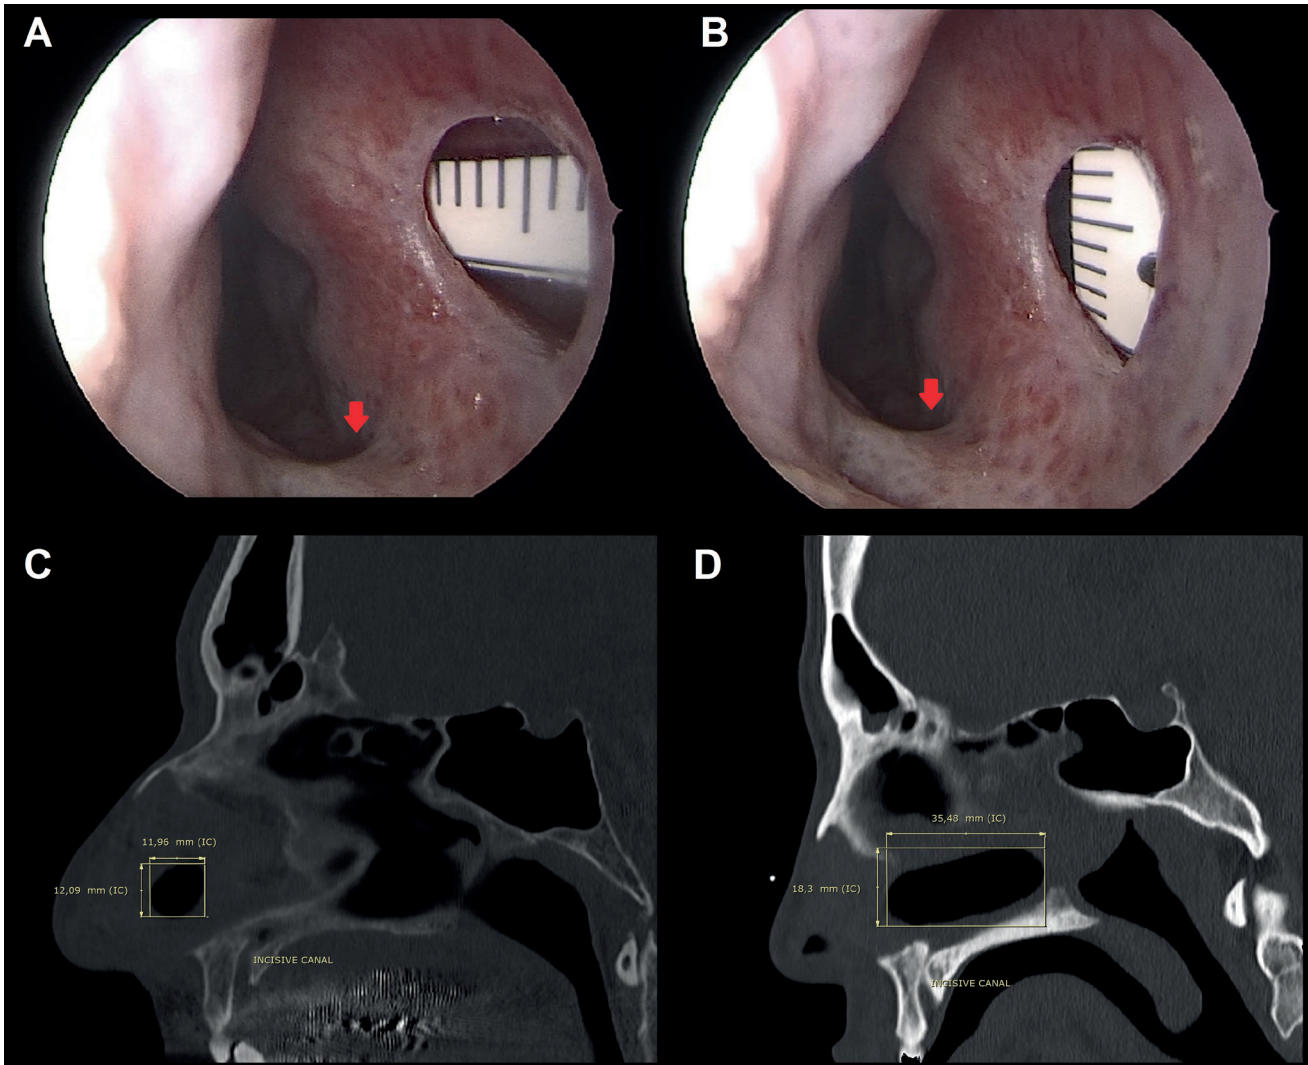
Assessment of NSP measurements by nasal endoscopy and sinus CT scan. A) Endoscopic assessment of anteroposterior distance (length). B) Endoscopic assessment of superoinferior distance (height). NSP position is determined based on the location of the NSP posterior edge relative to the incisive canal (red arrow). C) Sagittal plane of sinus CT scan showing an anterior NSP: the posterior edge is located anterior to the incisive canal. D) Sagittal plane of sinus CT scan showing a posterior NSP: the posterior edge is located posterior to the incisive canal.
